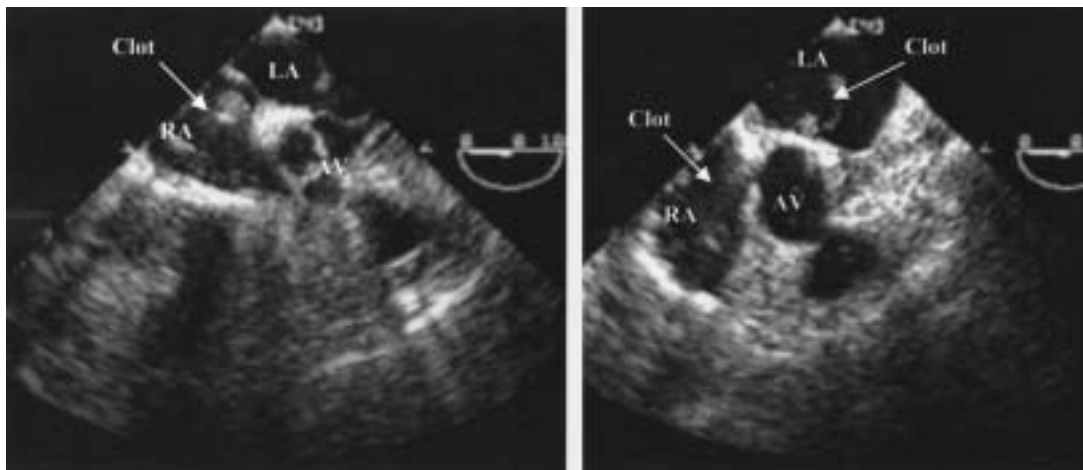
Transesophageal echocardiograms of a clot (arrows) traversing a patent foramen ovale. AV = aortic valve; LA = left atrium; RA = right atrium.
